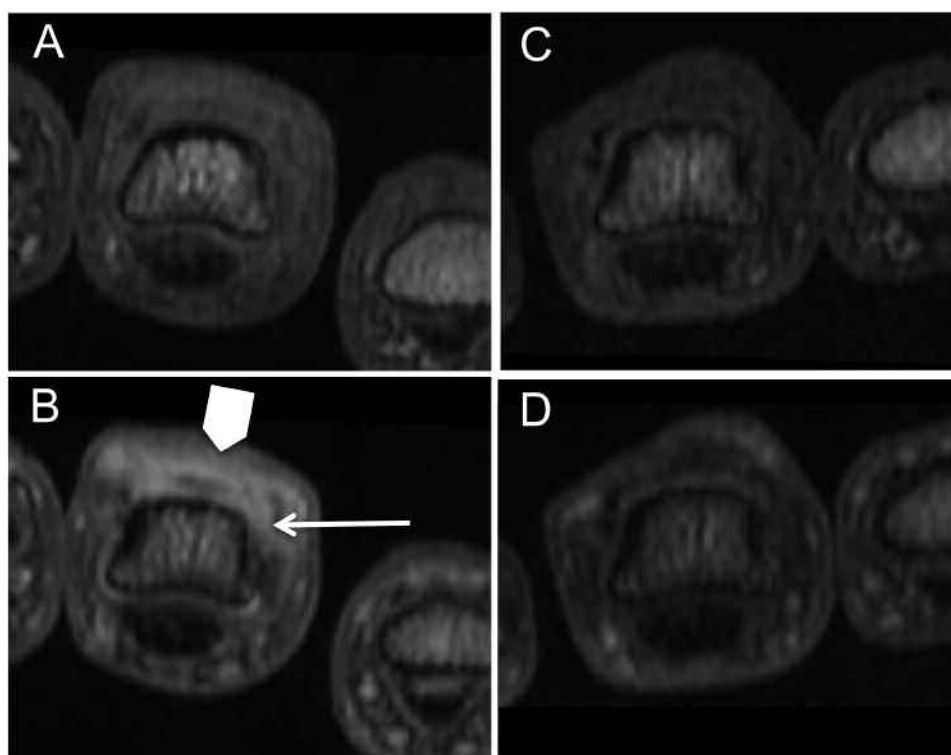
Magnetic resonance imaging examples of PsAMRIS's sensitivity to change during anti-TNF- α treatment. The T1-weighted images show before (A and B) and after (C and D) gadolinium injection. Baseline MR images of PIP-3 (A and B) show periarticular inflammation (broad arrow, B) and synovitis (narrow arrow, B). After 12 months with anti-TNF- α treatment (C and D) the periarticular inflammation and synovitis of the PIP-3 resolved.
